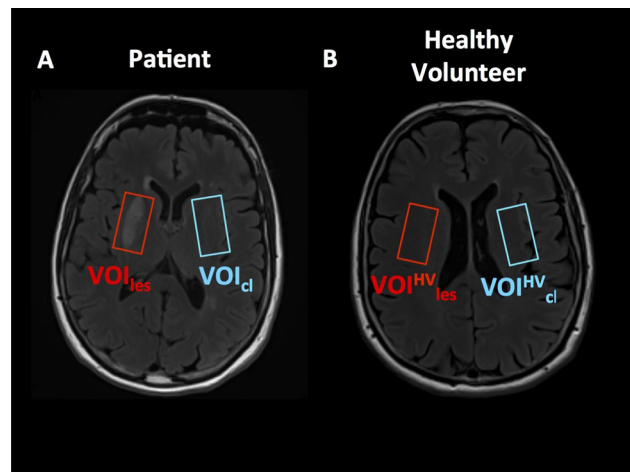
Examples of VOI locations in a patient (A) and in a healthy volunteer (B) shown on an axial view of a FLAIR image. In the HVs, VOIs were positioned in the same locations as for the corresponding age- and gender-matched patients.
